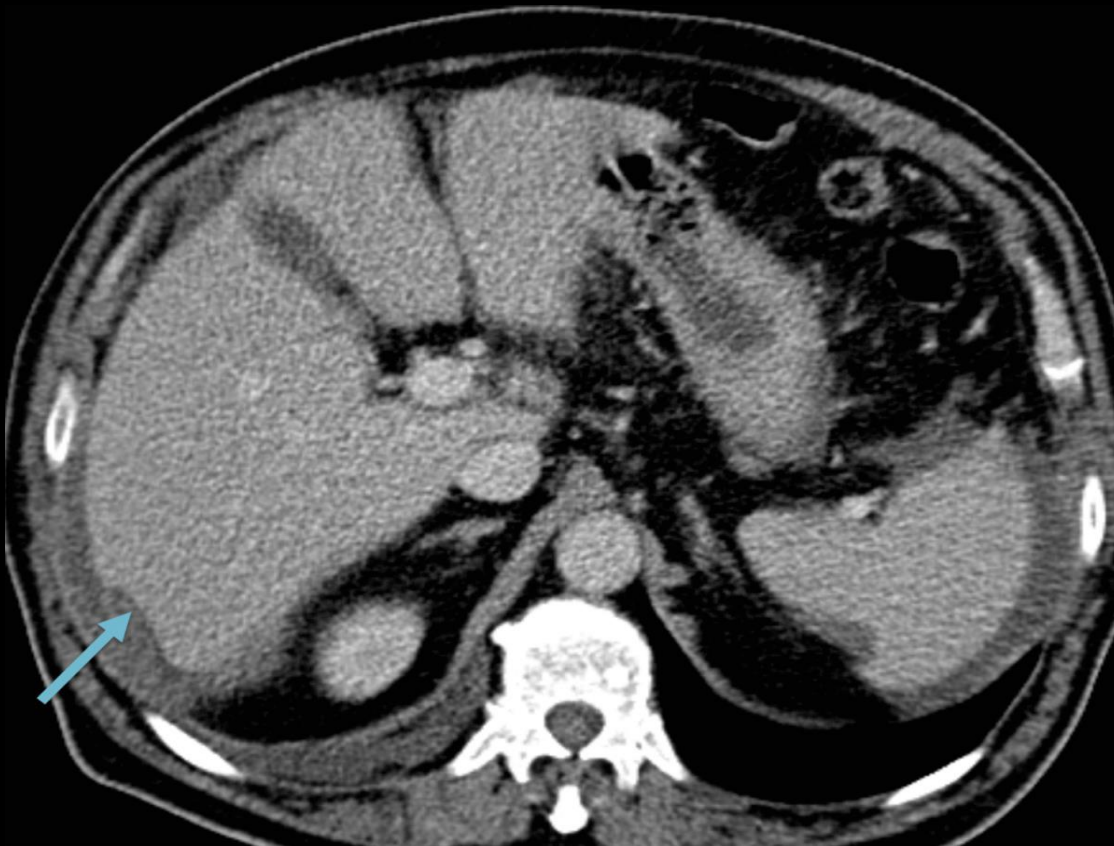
Pseudomyxoma peritonei. Axial CT image of a patient with a history of mucinous adenocarcinoma of the appendix shows small amount of perihepatic and perisplenic fluid. Note the mass effect (scalloping) on the posterior surface of the liver (arrow). This is characteristic of pseudomyxoma peritonei.
